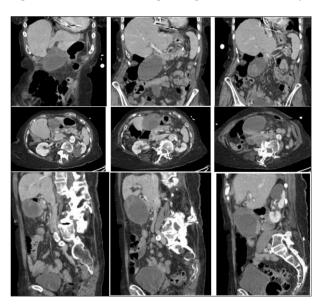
CT abdomen/pelvis demonstrating distended gallbladder and cholelithiasis. *A-C:* Coronal slices from anterior (A) to posterior (C). *D-F:* Axial images from superior (D) to inferior (F). *G-I:* Sagittal images from approximate midline (G) to right lateral (I).
